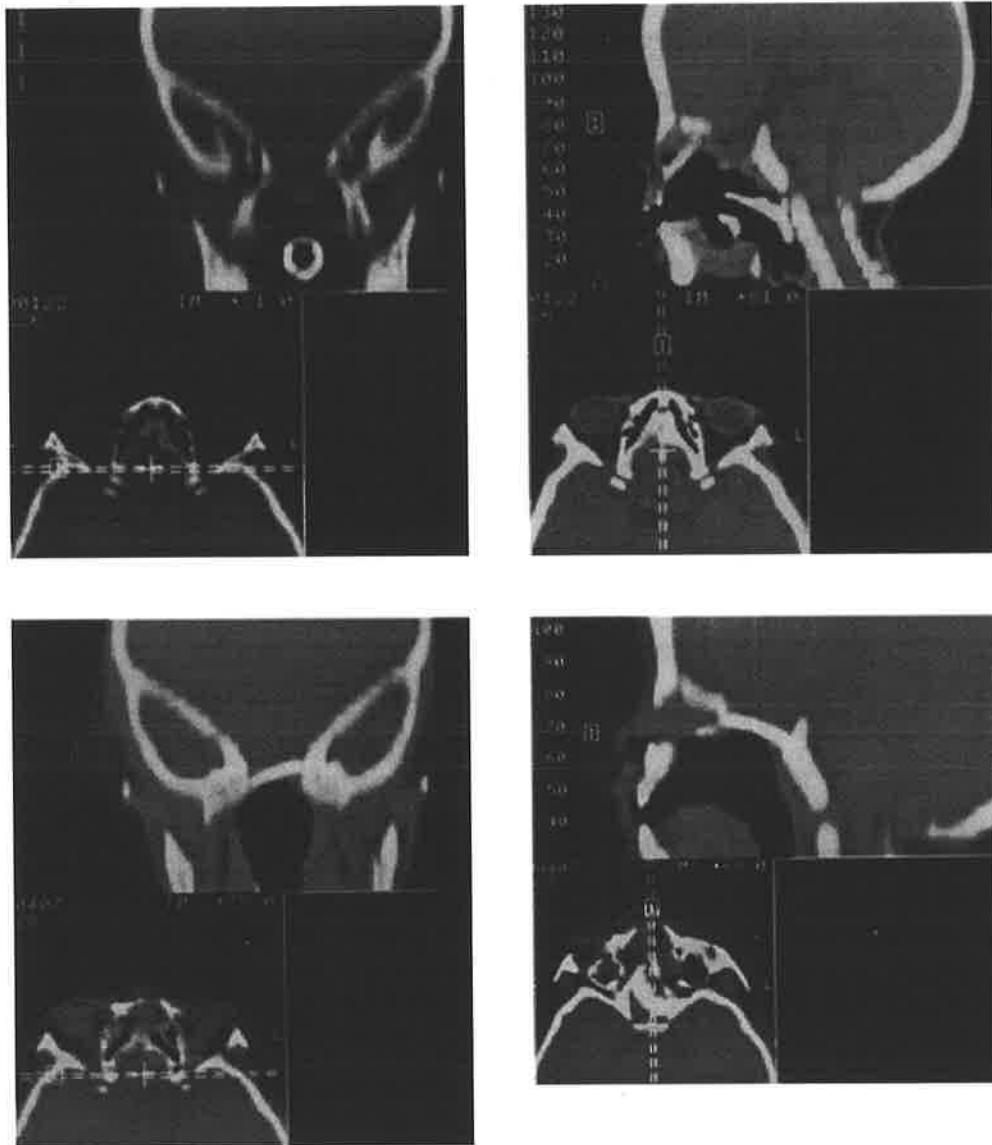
A. CT scan of 2 year old child with a trans-sphenoidal meningo-encephalocoele, coronal view. B. CT scan of 2 year old child with a trans-sphenoidal meningo-encephalocoele, sagittal view. C. CT scan of 2 year old child after correction of trans-sphenoidal meningoencephalocoele, demonstrating the bone graft in situ, coronal view. D. CT scan of 2 year old child after correction of trans-sphenoidal meningo-encephalocoele, demonstrating the bone graft in situ, sagittal view.*
